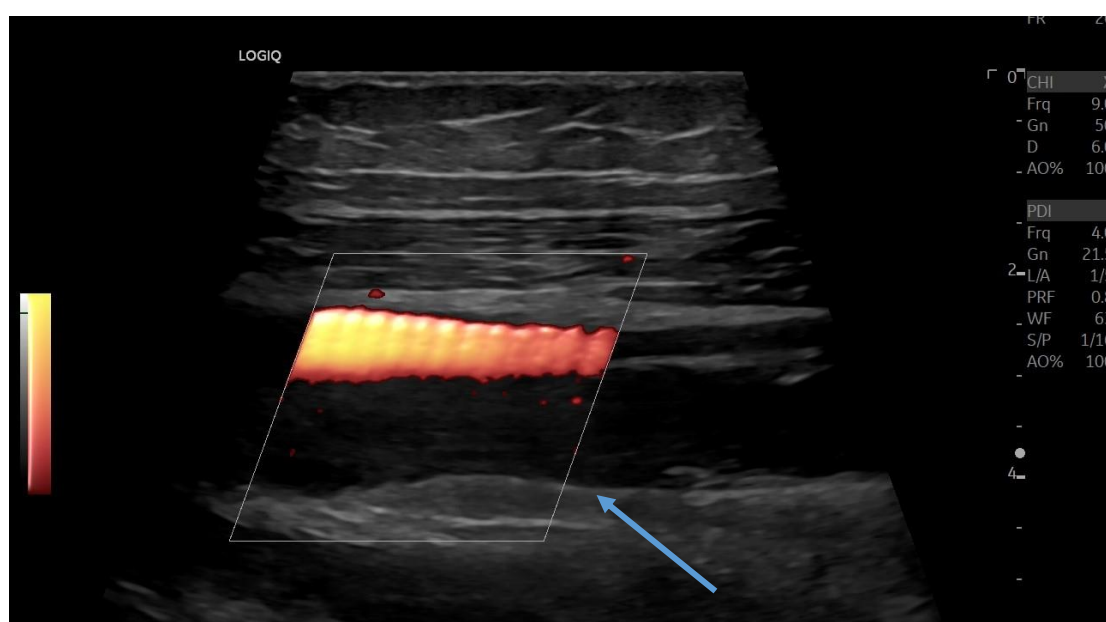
Power doppler image on longitudinal plane exhibiting the absence of flow inside the thrombosed CFV (blue arrow).
